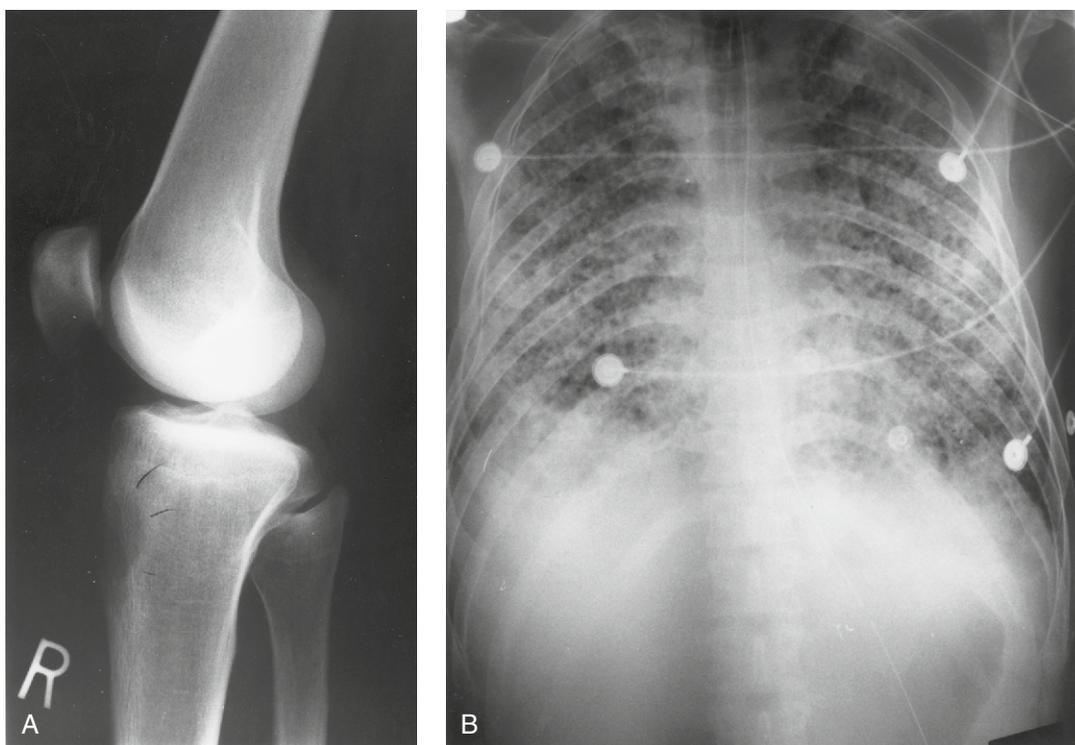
(A) Well-circumscribed lytic bone lesion in the proximal tibia of a 32-year-old man with AIDS due to *C. immitis*. The patient complained of severe shortness of breath and focal pain of the knee. Examination of the knee revealed no evidence of erythema or dolor, but the tibial tuberosity was exquisitely tender. (B) Severe miliary pulmonary disease was seen on chest radiograph. *C. immitis* has a predilection for bone prominences, such as the tibial tuberosity.
